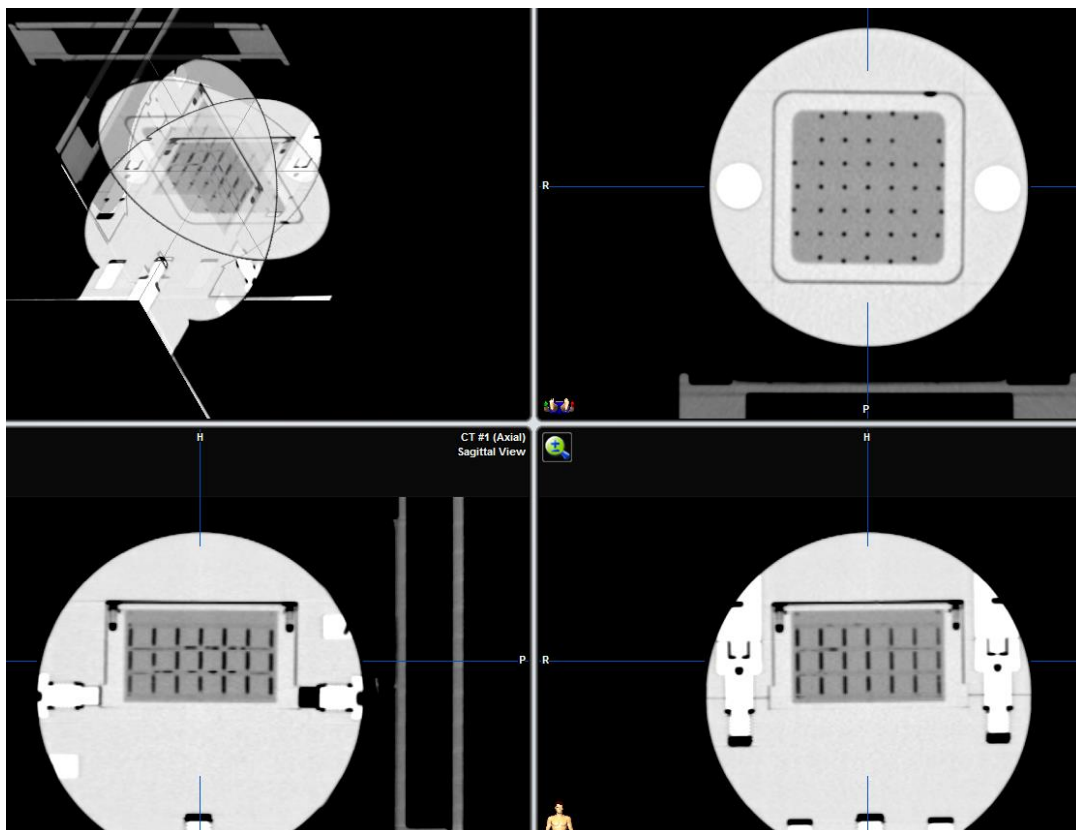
CT scan of grid insert imported into the treatment planning system. Shown are (clockwise from top left): 3D, axial, coronal and sagittal views.
